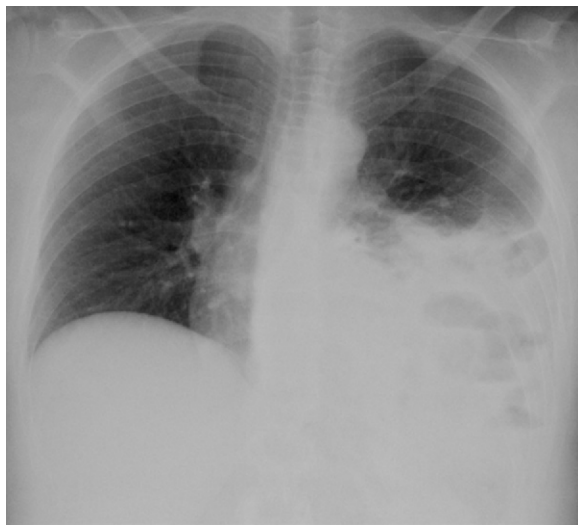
Left-sided BDR in a 19-year-old woman (same patient as in Fig 3). Chest radiograph shows obliteration of the left hemidiaphragmatic contour with elevation of gas-containing structures from the gastrointestinal tract above the expected level of the left hemidiaphragm and a resultant slight mediastinal shift toward the right side.
